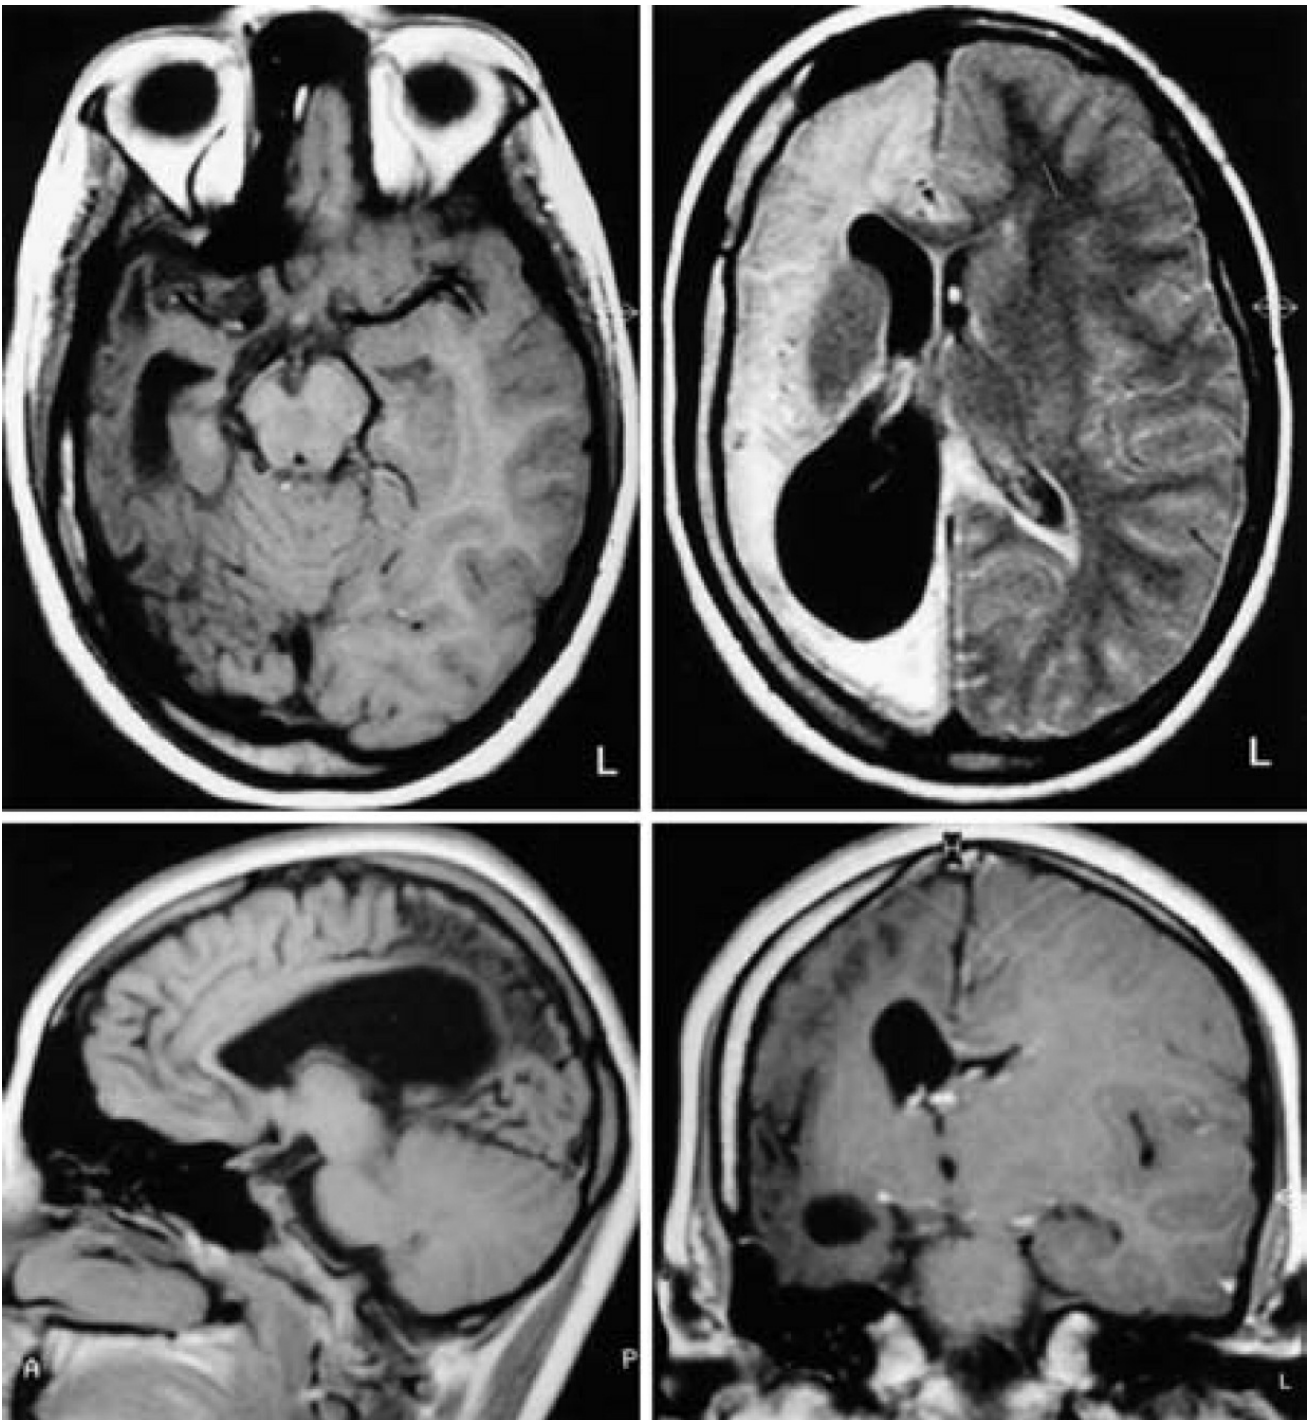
Preoperative MR images obtained in a 16-year-old girl, demonstrating atrophy of the right hemisphere and an enlarged right lateral ventricle. (Images courtesy of AL Rhoton, Jr.)
